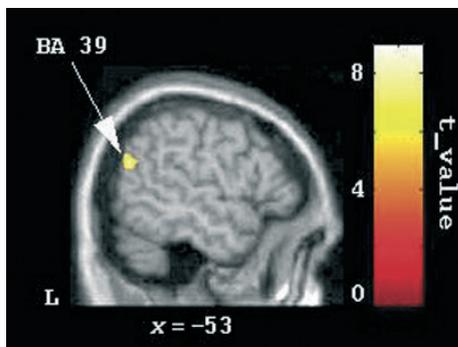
Results of VBM analysis comparing the scans obtained from mountain climbers before (baseline) and after (follow-up) an extremely high-altitude expedition. A reduction in GM density is detectable in the left angular gyrus (BA 39). Here we report the thresholded map of t -statistic values (sagittal section, $x = -53$) of this region superimposed on the single-subject T1-weighted normalized brain of SPM. L = left.
